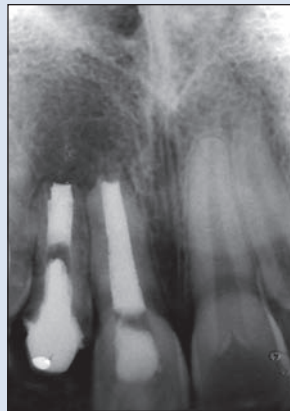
Preoperative diagnostic radiograph in case 1 showing teeth 11 and 12 with open apices and periapical radiolucencies. Tooth 12 presents over-extension of gutta-percha points.
